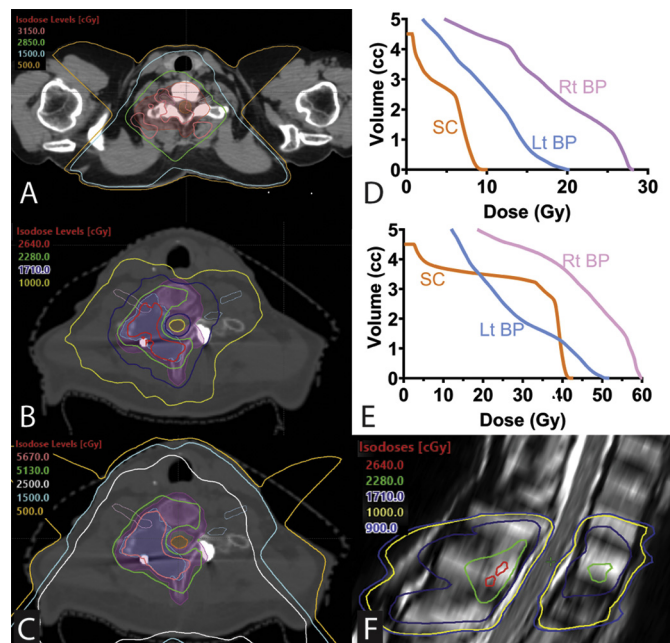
CT slices with plan doses, right and left brachial plexus (Rt BP and Lt BP, respectively), spinal cord (SC), and planning target volume contours for the (A) initial conventional external beam radiation therapy plan, (B) the reSBRT, and (C) the plan sum. (D, E) The dose-volume histograms for the SC for the reirradiation with stereotactic body radiation therapy for the patient who developed bilateral peripheral neuropathy. (F) Follow-up T2 magnetic resonance imaging taken 8 months after reirradiation with isodose lines from the reirradiation plan.
